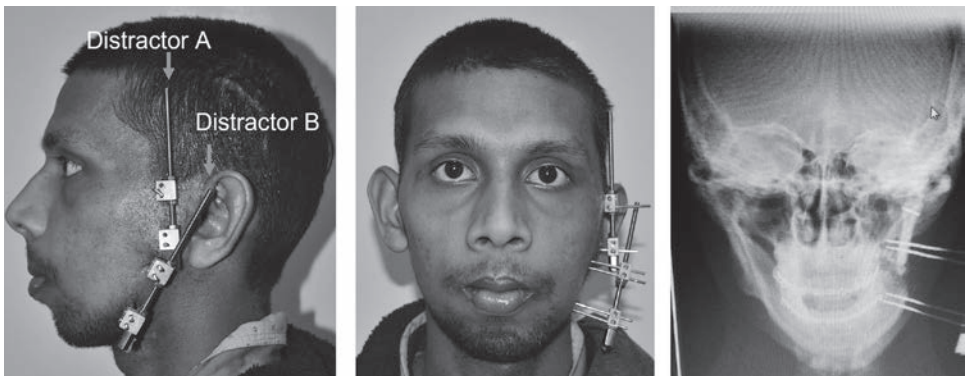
Interdistraction photographs showing dual distraction and radiographs taken during consolidation phase after distraction.
